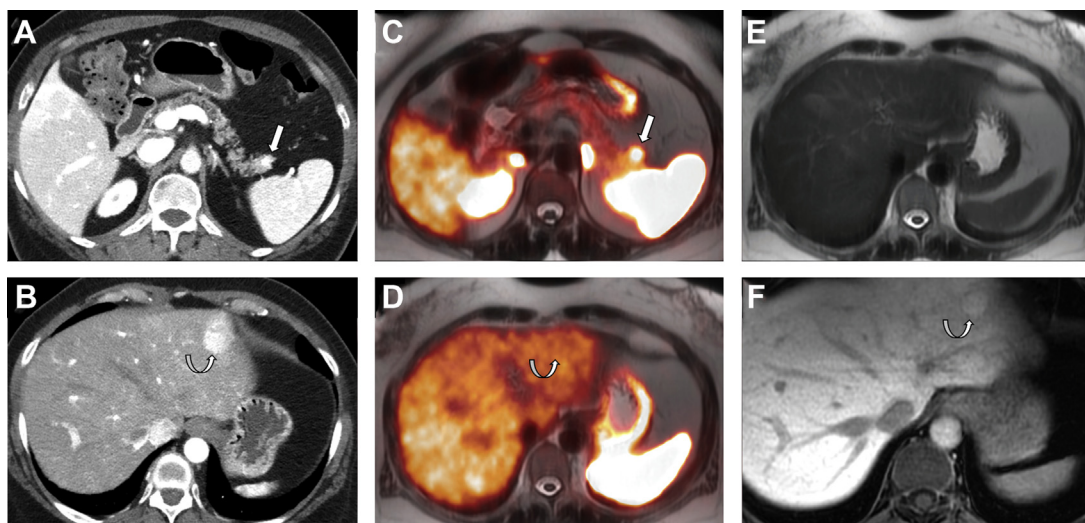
Patient with suspected pancreatic tail NET on contrast-enhanced portal venous phase CT scan (A) and possible hepatic metastasis on contrast-enhanced arterial-phase CT scan (B). Subsequent [^{68}Ga]DOTATATE-PET/MR imaging shows focal activity (arrow) in the pancreatic tail NET (C) and no activity in the suspected liver metastasis (curved arrow) (D). Corresponding T2-weighted (E) and hepatobiliary phase T1-weighted postcontrast MR images (F) demonstrate no increased T2 signal in the liver lesion, which demonstrates hepatobiliary phase contrast retention (curved arrow), consistent with focal nodular hyperplasia.
